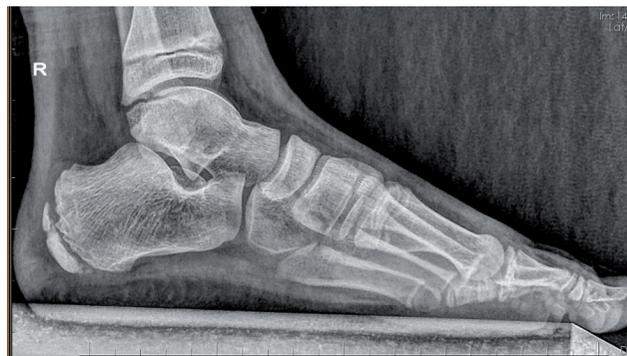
X-ray of sclerosis in the calcaneal apophysis with fragmentation.
